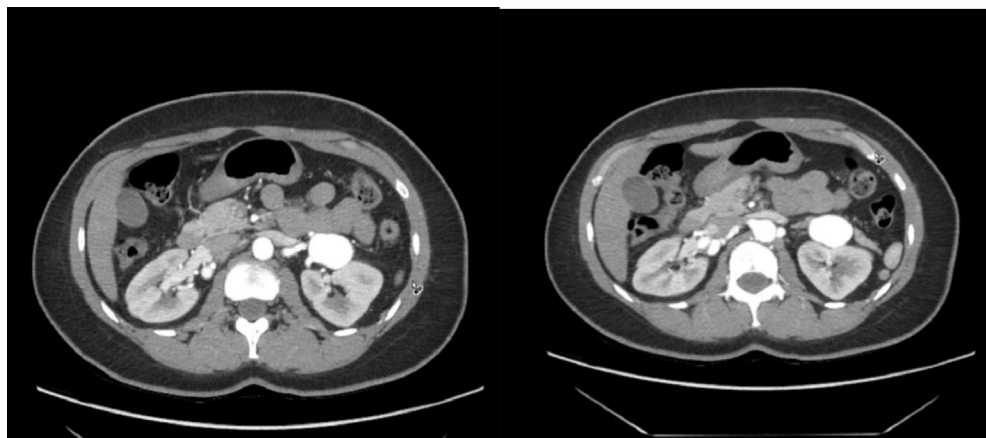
Preoperative computed tomography angiography showing the renal artery branches from the left renal artery aneurysm (RAA; *left*) and the bilobed nature of the right RAA (*right*).
